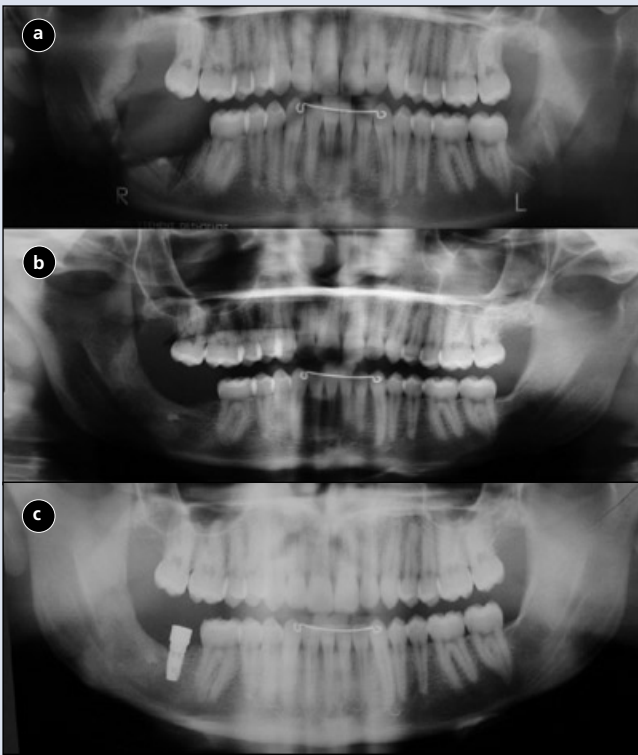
(a) Panoramic radiograph demonstrating a defect in the right posterior mandible of a 19-year-old man whose ameloblastoma was removed using an intraoral approach in the right retromolar region. (b) A year after reconstruction of the right posterior mandible using a BMP bioimplant, complete restoration of the region of the defect is seen. (c) Four months following placement of a dental implant into a reconstructed region of the right posterior mandible, the implant has successfully integrated into the newly regenerated bone.
